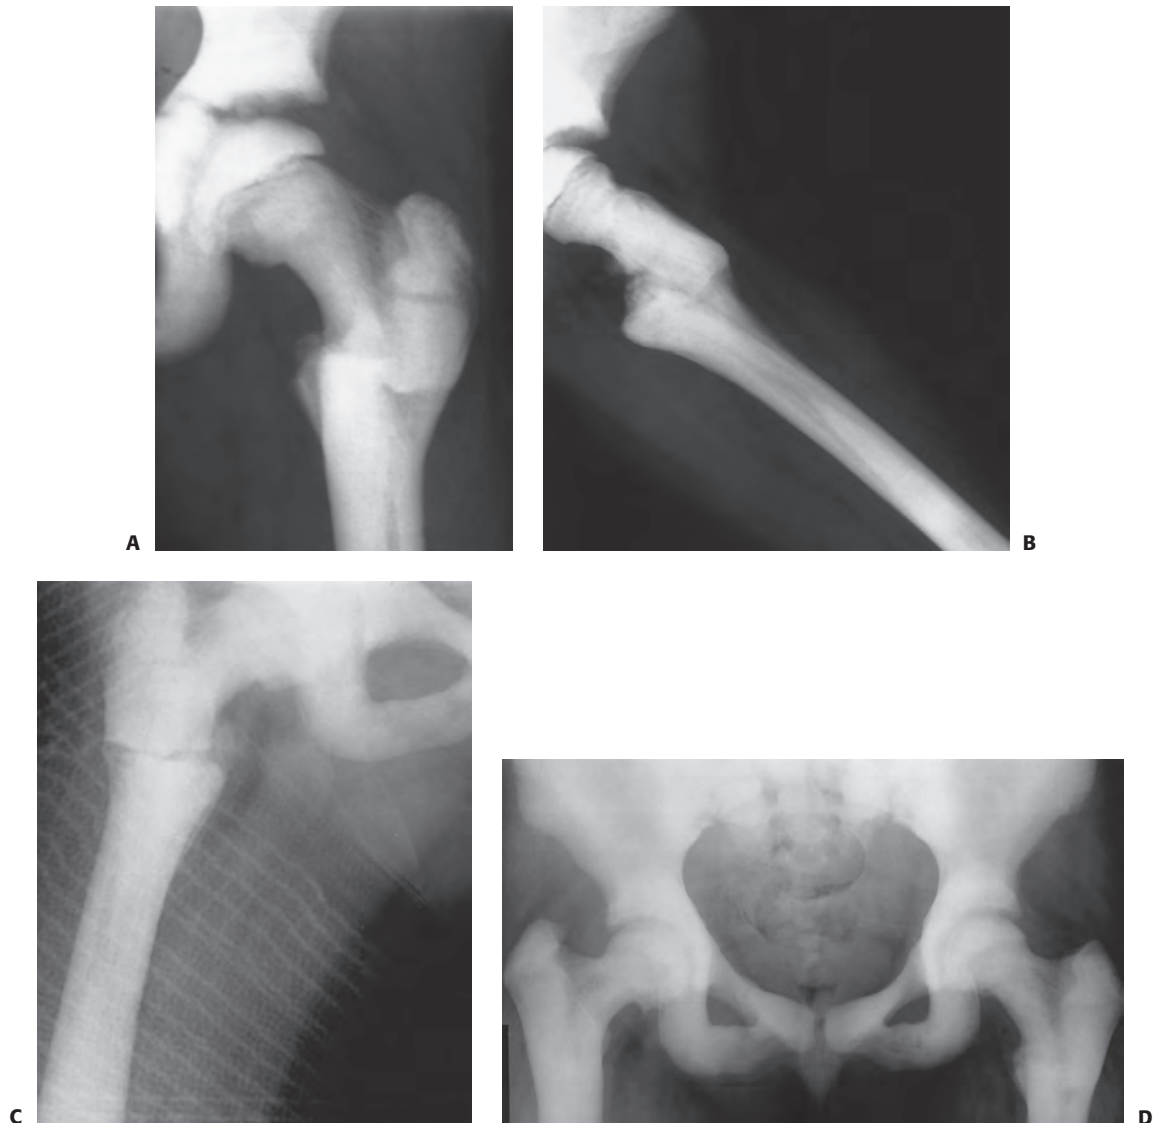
A: This 9-year-old with osteopetrosis sustained similar bilateral subtrochanteric fractures of the femur over a 2-year period. Anteroposterior (A) and lateral (B) femoral radiographs show a healing transverse subtrochanteric fracture of the left femoral. C: One year later, at age 10, she sustained a similar right transverse minimally displaced subtrochanteric femur fracture, which was treated with reduction and a spica cast. D: This anteroposterior radiograph taken at age 14 years shows that both proximal femoral fractures have healed and there is mild residual coxa vara, especially on the right side.
